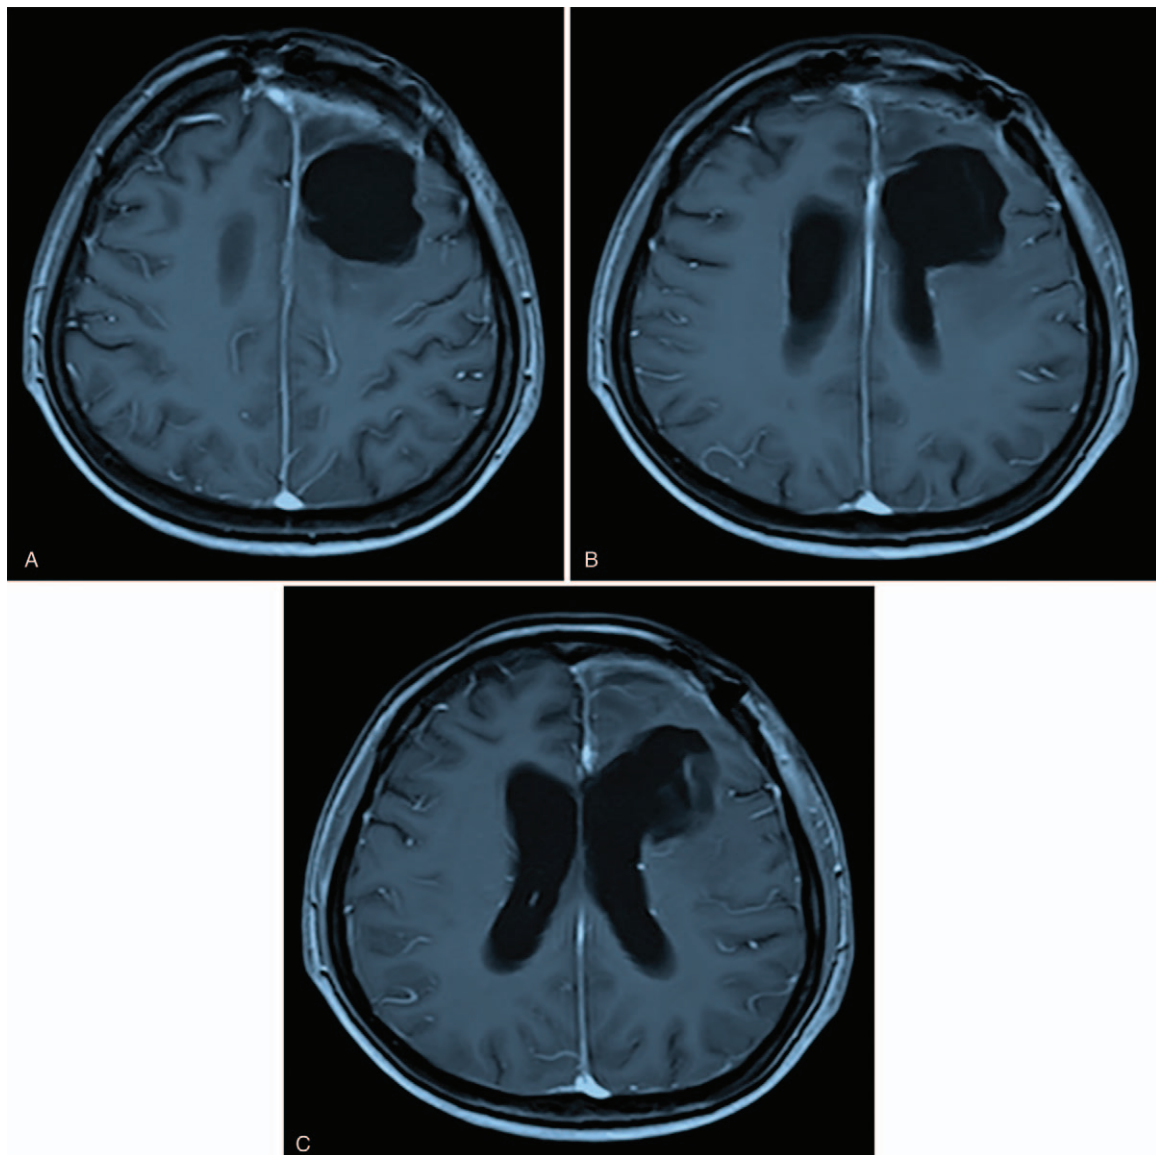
(A–C) Magnetic resonance imaging (MRI) of the patient 1 month after radiotherapy.
